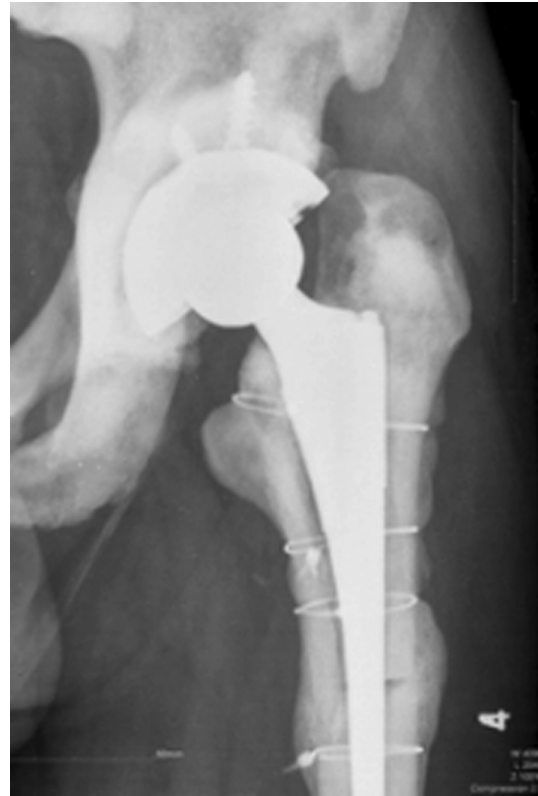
AP radiograph of pelvis showing no subsidence of the prosthesis and good callus formation at 12 weeks after the periprosthetic fracture.
